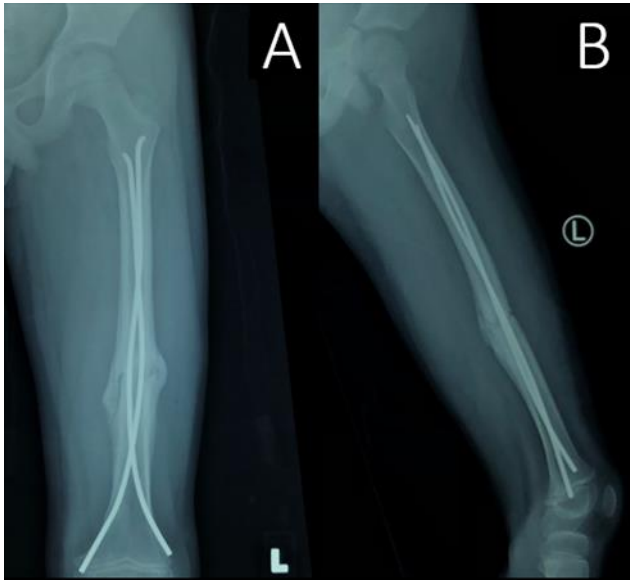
X-Ray left femur post-op 3 months. (A) Antero-posterior view, (B) Lateral view
